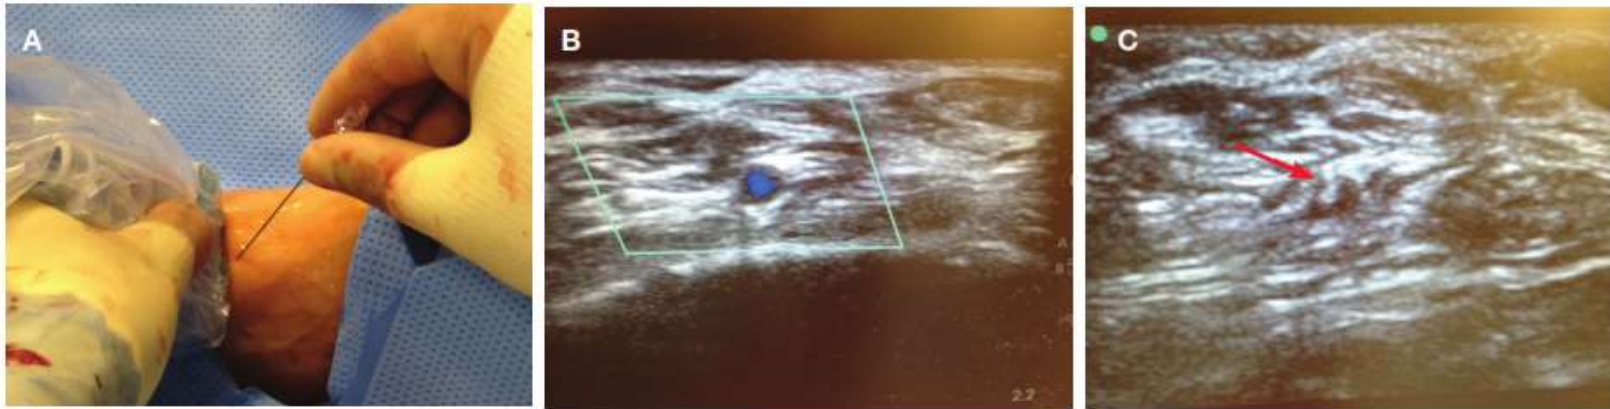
Duplex ultrasound-guided access into the dorsalis pedis artery. (A) Duplex ultrasound probe and 21-gauge needle in place. (B) Color duplex identifies the patent anterior tibial artery lumen. (C) Tip of the needle inside the vessel on ultrasound (red arrow).
